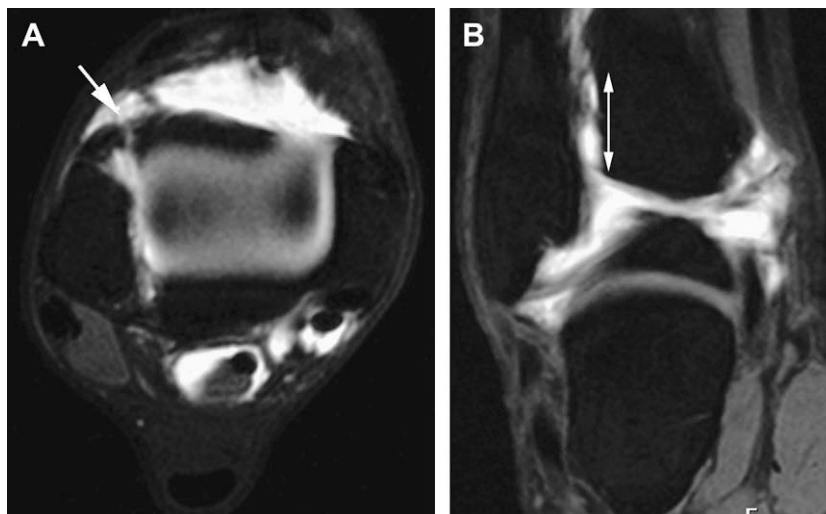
Chronic syndesmosis sprain. (A, B) Axial and coronal fat suppressed T1-weighted images of right ankle show thickening and complete disruption of the AITF (arrow), and increase in the height of the tibiofibular recess (double-headed arrow).
